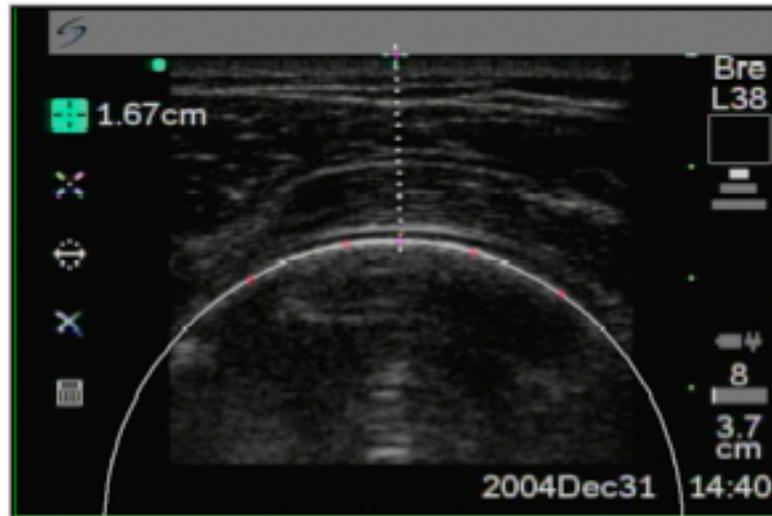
Ultrasound Image with Circular Fit
